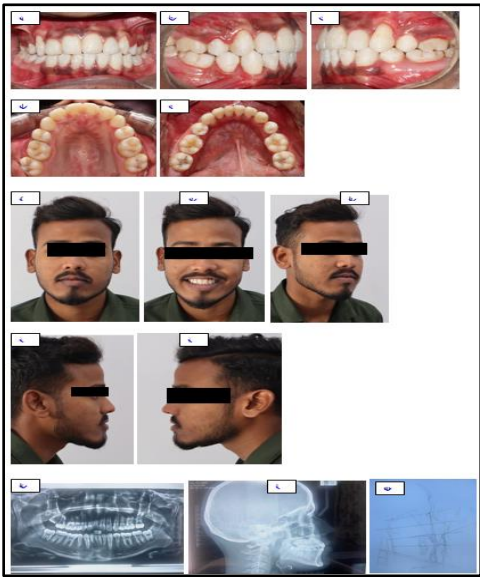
Post-treatment- intra-oral photos (a-e), extra-oral photos (f-j), panoramic radiograph (k), lateral cephalogram (l), cephalometric tracing(m)
